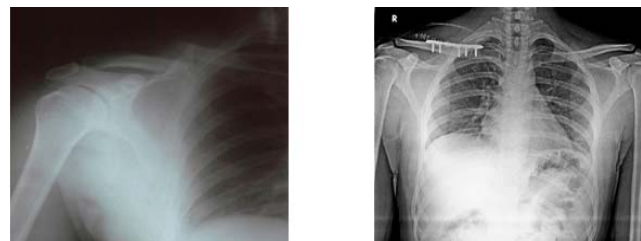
Pre-operative and post-operative xray films
